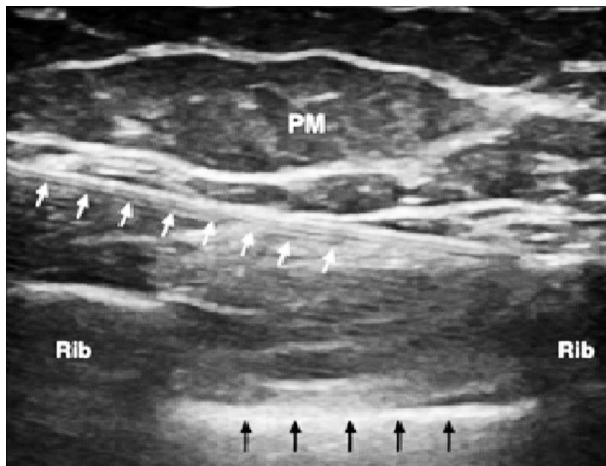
Ultrasound image of pecto-intercostal fascial block. Pectoralis major (PM) and the third and fourth costal cartilages are demonstrated. The needle (white arrows) was advanced in the cephalad direction while injecting local anesthetics underneath the PM starting from the fourth costal cartilage level. Black arrows: pleura.
